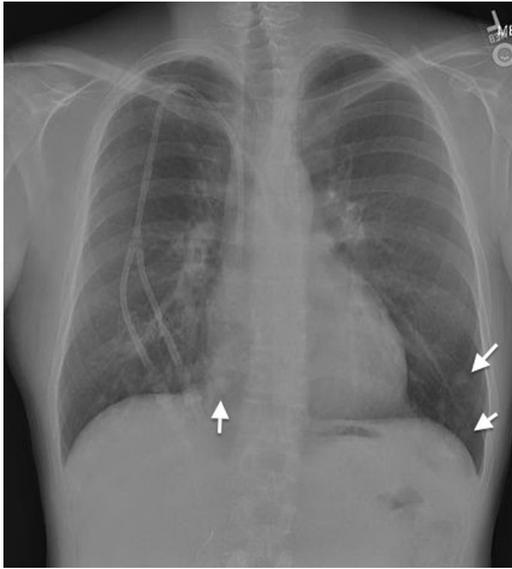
Chest radiograph at the time of admission revealed basilar nodules (arrows) which had not been visible on a radiograph obtained 6 weeks prior.
